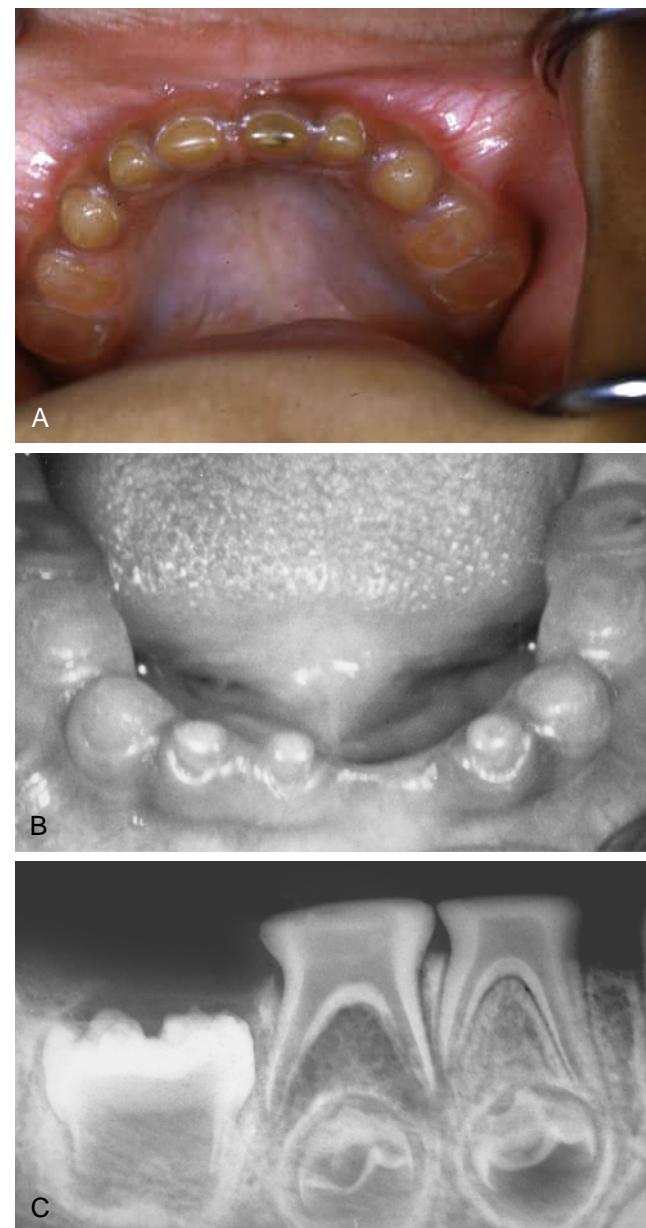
(A and B) Severely abraded teeth are almost entirely devoid of enamel. The outline of a large pulp chamber can be seen through a thin covering of dentin. The mandibular second primary molars have pulp exposure. (C) Radiograph shows large pulp canals and large pulp chambers. Apical rarefaction is associated with pulp exposure of the second primary molar.
